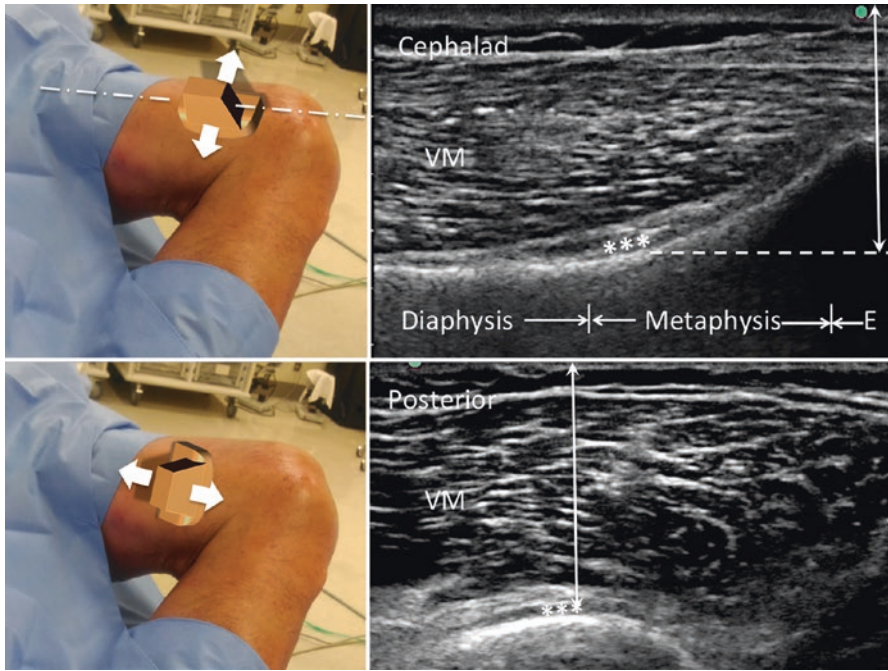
Ultrasound imaging technique and the corresponding sonographic image of the superomedial knee. Upper left panel. The ultrasound probe was placed along the long axis of femur between the diaphysis and epiphysis. Upper right panel. A fascia expansion (*) deep to the vastus medial (VM) could be seen. E, epiphysis. Lower left panel. The ultrasound probe was then turned 90 °C to obtain a short-axis view of the femur. Move or align the probe in the cephalad-caudal direction until the target of the same depth as the long-axis view is obtained. It is important that the probe should not be tilted but aligned in cephalad-caudal direction. When the appropriate depth was found, the same fascia expansion (*) could be located. (Reprinted with permission from Philip Peng Educational Series)
